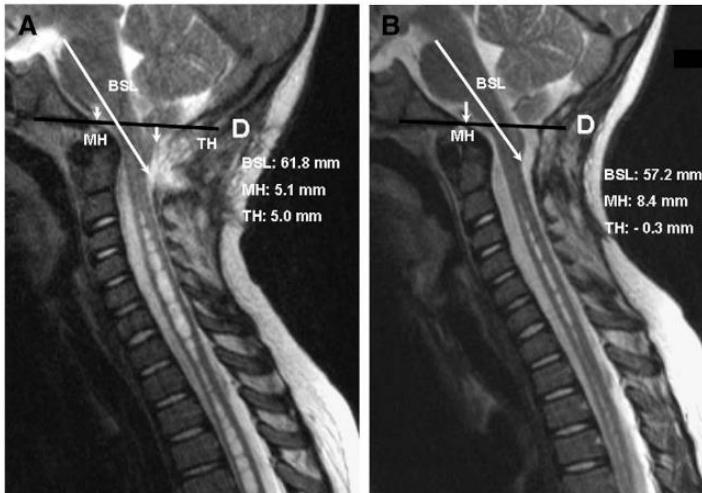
Morphometric measurements of CCJ before and after SFT in 8-year-old female with CM-I/TCS and slowly progressive syringomyelia 3 years after Chiari decompression surgery had failed to reduce syrinx size. Reconstructed CT scans of head revealed complete recossification of suboccipital craniectomy. A: Midsagittal T-2 weighted MR image before SFT showing elongation of brain stem (BSL = 61.8 mm), downward displacement of medulla (MH = 5.1 mm), herniation of cerebellar tonsils (TH = 5.7 mm), and persistent cervicothoracic syringomyelia. B: Postoperative scan 5 weeks after SFT showing reduction of BSL (57.2 mm), ascent of medulla (MH = 7.4 mm), ascent of cerebellar tonsils (TH = 0), expansion of upper cervical subarachnoid spaces, and reduction in size of syringomyelia.
